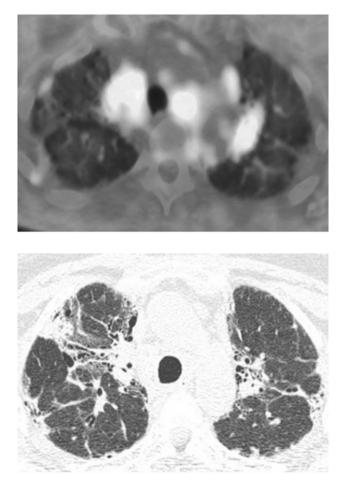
Example of pulmonary PET-positivity in a 45-yearold female sarcoidosis patient with fibrotic changes on HRCT. The transversal PET/CT fusion image at thoracic level (upper image) shows areas of FDG accumulation bilateral in the hilar regions and in several mediastinal lymph nodes. The HRCT image (lower image) at the same level shows architectural parenchymal distortion with parenchymal opacities, thickening and irregularity of the bronchovascular bundle, irregular pleural thickening and in the left lung a limited area of honeycombing.
